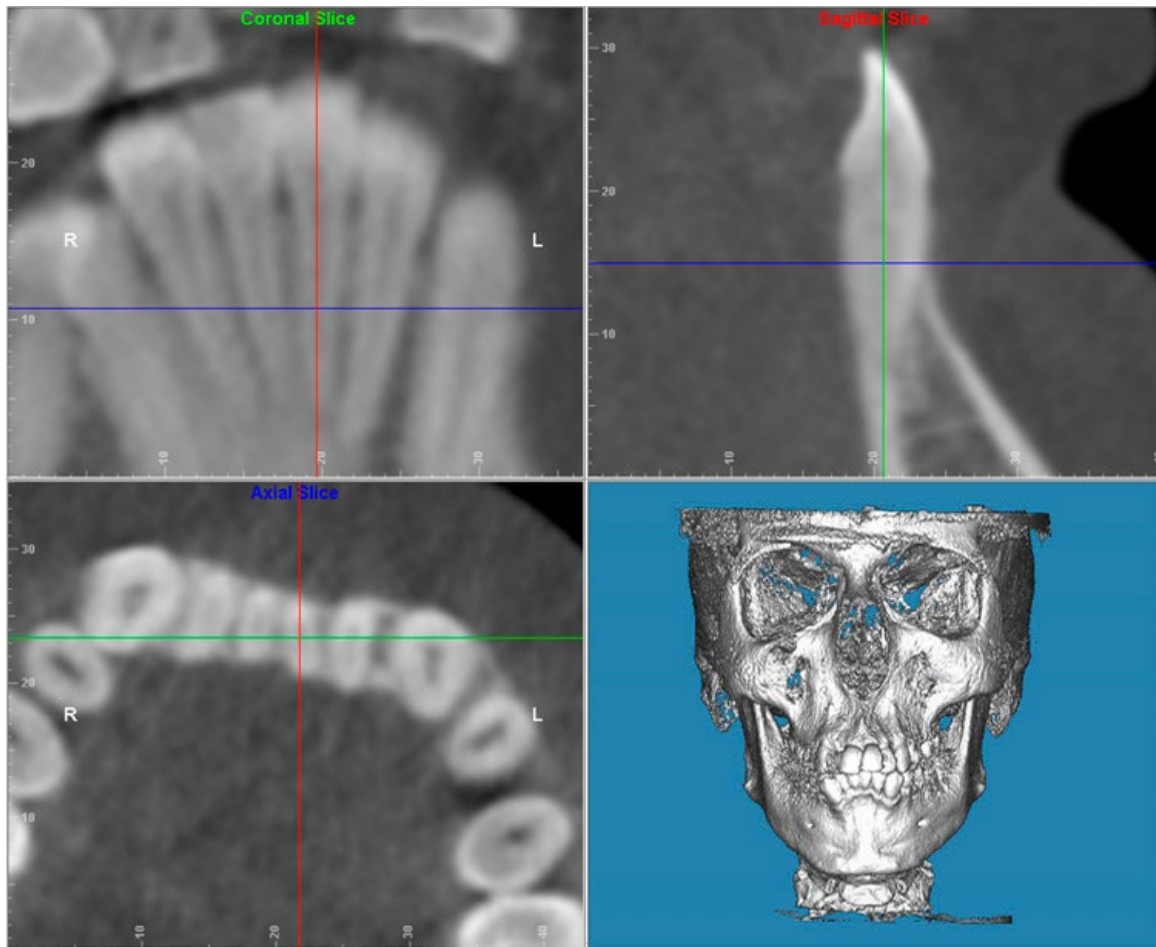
Cone-beam computed tomography scan oriented along the long axis of the tooth in all 3 planes.
